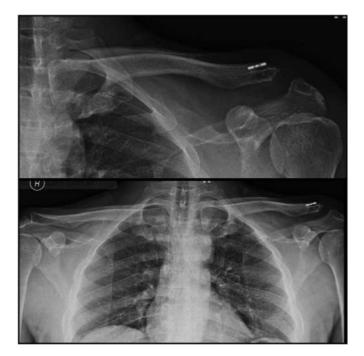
Post-operative radiograph at 1 year showing a reduced AC joint.
